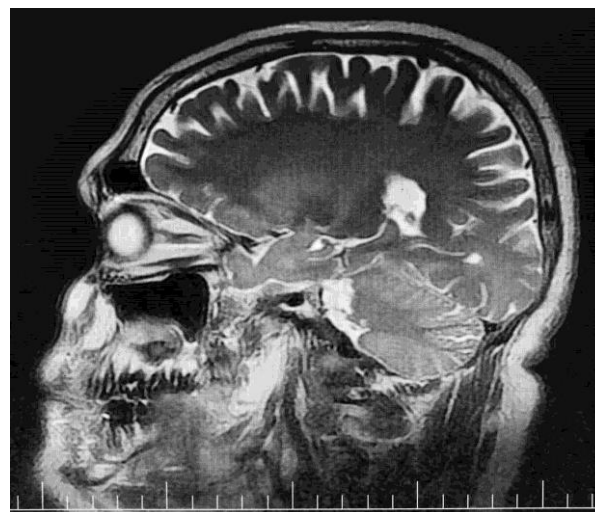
Sagittal view of patient's brain magnetic resonance imaging (MRI)
